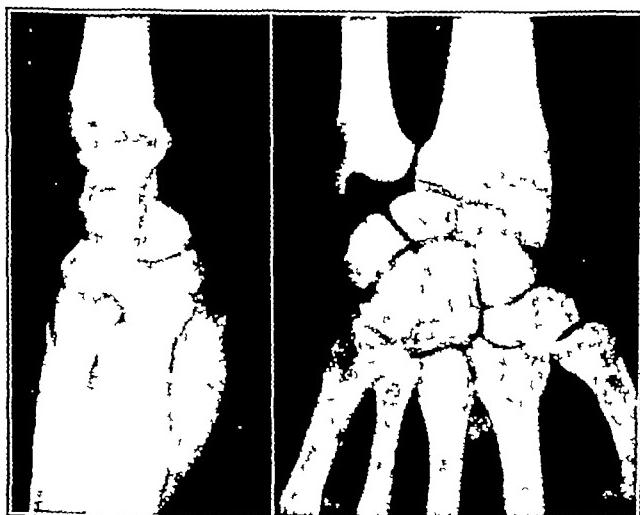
(case 11).—Roentgenograms taken March 24, 1944, eight and a half months after the injury, shows fracture across the proximal pole of the scaphoid. The fracture line is distinct.
